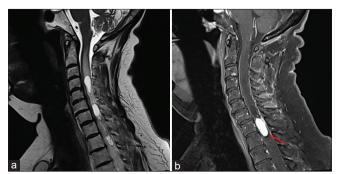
Magnetic resonance imaging of the cervical spine. (a) Sagittal T2-weighted revealed a syrinx with an intramedullary expansive lesion. (b) Sagittal T1-weighted dixon Gadolinium (Gd) enhancement image revealing an intramedullary intradural hyperintense mass (red arrow) at the T1-T2 level.
